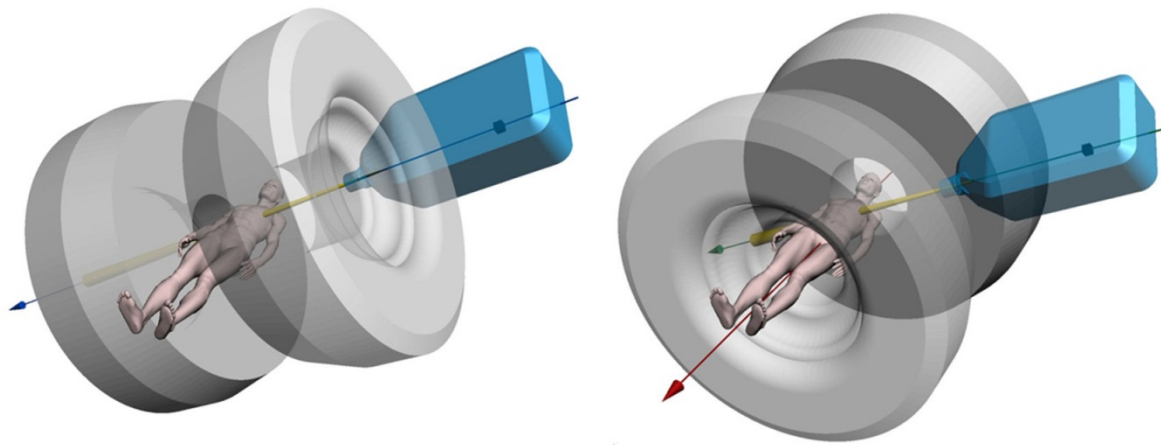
Conceptual layout of a linac (blue) with respect to an MRI scanner. There are two possible locations of the linac (A) the in-line orientation, in which the fringe field from the magnet points in the same direction as the electron being accelerated, and (B) the perpendicular configuration, in which the electron motion and fringe field are at right angles. Figure taken from [24].
